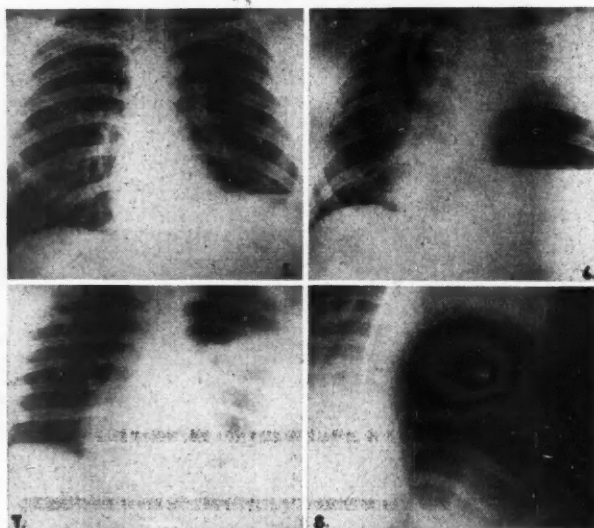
(Case 2).—Shows what appears to be an adherent left diaphragm. Fig. 6. (Case 2).—Mediastinum shifted to the right and a fluid level in left chest. Fig. 7. (Case 2).—X-ray of chest showing gas in stomach once more. Fig. 8. (Case 2).—Shows a markedly dilated stomach. Tube has slipped out of the stomach.
